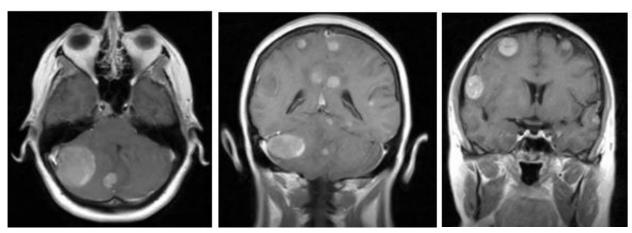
T1 axial and coronal with gadolinium Brain MRI showing multiple brain metastatic lesions.
